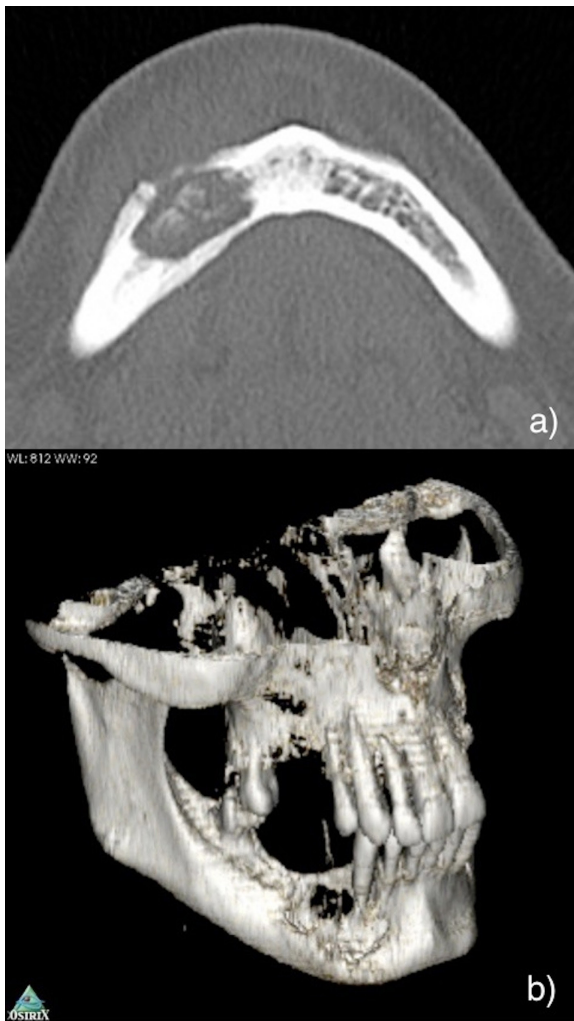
Computed Tomography (CT) scan (A) and 3D reconstruction (B) showing an osteonecrosis that involve vestibular and lingual plates
